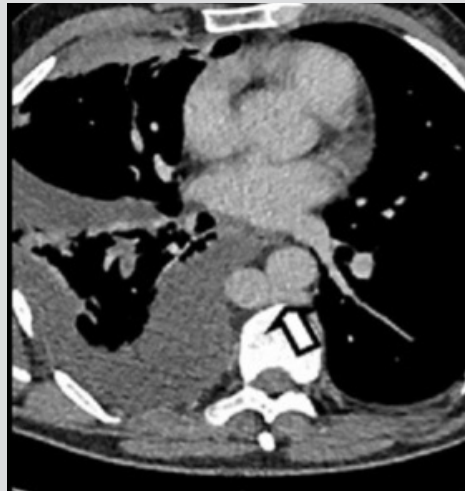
Axial contrast-enhanced CT of the abdomen showing a complex right-sided pleural effusion and incidental hemiazygos vein emptying into the azygous continuation of the inferior vena cava (open arrow) in the retroaortic space
